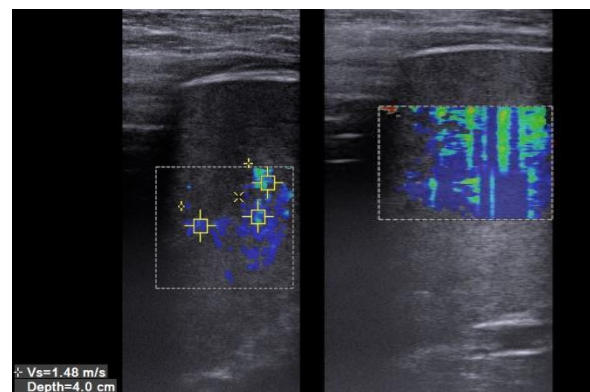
and 1g shows the additional findings of the shear wave sonography of the lesion.
